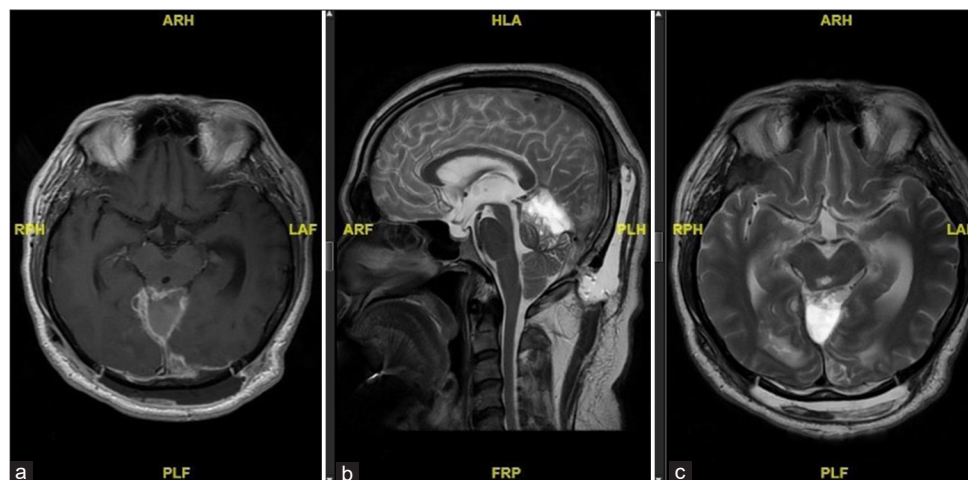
(a) Postoperative magnetic resonance imaging (MRI) T1-weighted axial view. (b) Postoperative MRI T2-weighted sagittal view. (c) Postoperative MRI T2-weighted axial view. Hyperintense posterior to the midbrain indicates the accumulation of cerebrospinal fluids.
